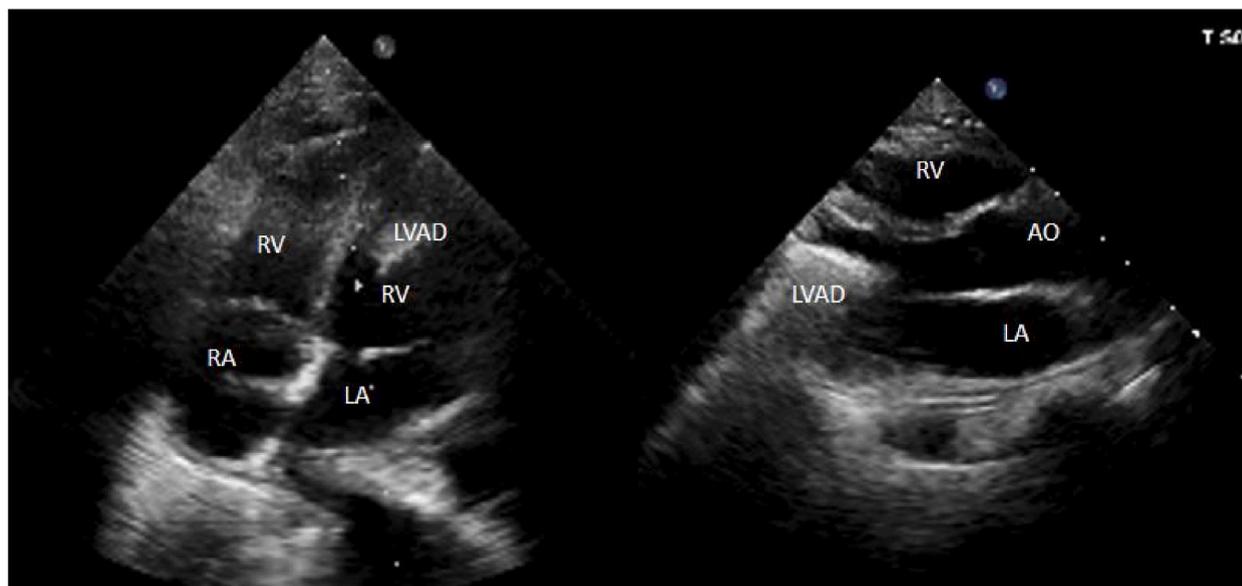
Transthoracic echocardiography before discharge showed progressive improvement in left ventricular function with an EF of approximately 40 % under LVAD support.
